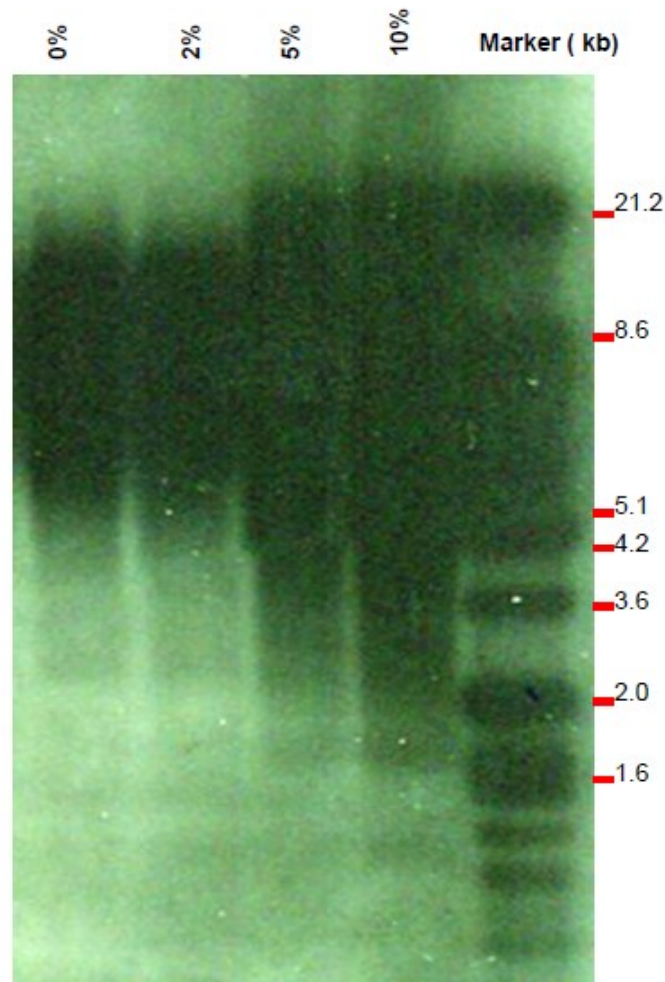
Telomere length analyses. After the exposure to CSC gingival fibroblasts were used to extract total DNA. The average telomere length was measured using the Telo-TAGGG Telomere Length assay. DNA was digested using a Hinf I / Rsa I restriction enzyme mixture then migrated on 0.8% agarose gel. Following southern transfer of digested DNA on nitrocellulose membranes, these were incubated with Anti-DIG-AP antibodies for 30 minutes. Detection was performed with chemiluminescence reaction and visualized on X-ray films and using a Chemicon Bioimaging system.
